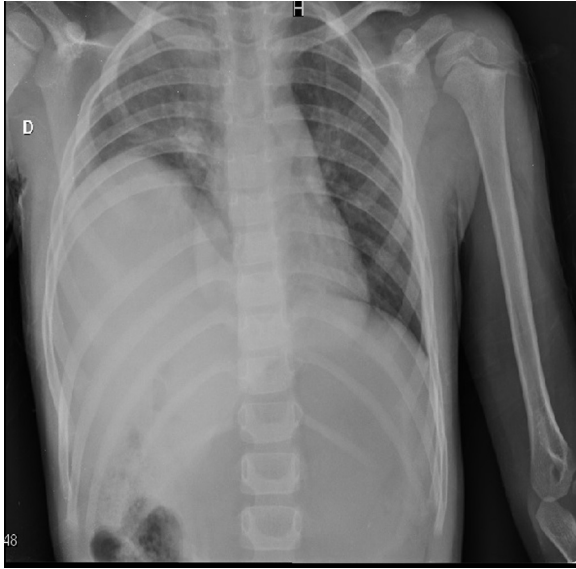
A simple chest radiograph showing a marked elevation of the right hemidiaphragm, suggesting a diaphragmatic hernia.
